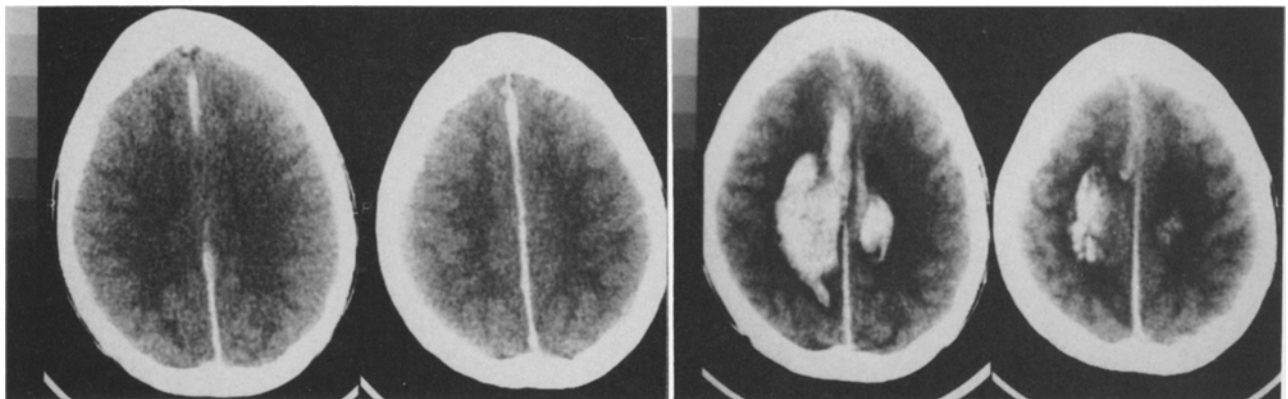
Case 2. *Left Pair:* Nonenhanced computerized tomography (CT) scans obtained on admission showing an interhemispheric subdural hematoma. *Right Pair:* Nonenhanced CT scans obtained on the 14th day after injury showing bilateral intracerebral hemorrhage.
